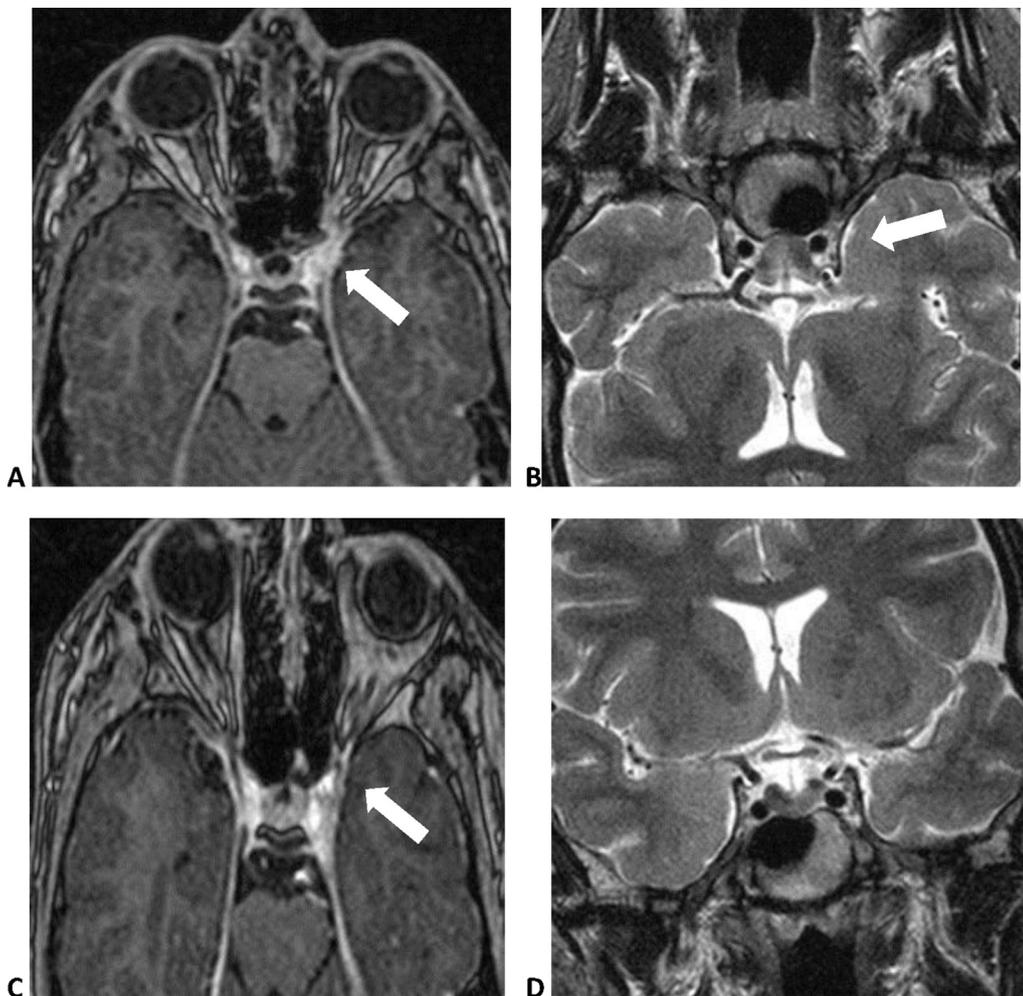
MRI axial imaging of a 14-year-old boy with left orbital pain, ptosis, diplopia, and third nerve palsy, four weeks after the diagnosis and treatment of ipsilateral seventh nerve palsy. MRI axial imaging without (A) and with (B) enhancement demonstrates granulomatous inflammation of the left cavernous sinus homogeneously enhancing after contrast administration. MRI findings normalized completely one month later (C, D). MRI, magnetic resonance imaging.
